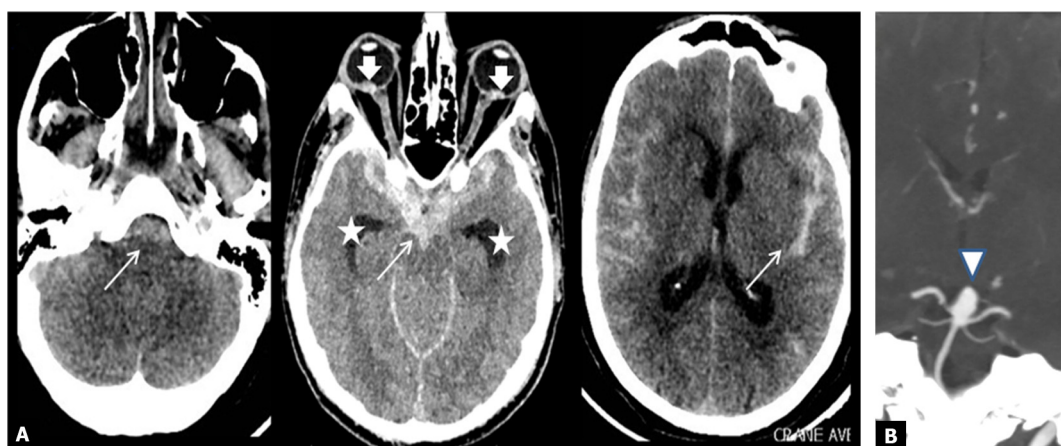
Axial cerebral CT without enhancement (A) and angiogram of the arterial circle at the base of the brain (B) on MIP reconstructions centered on the circle of Willis. Positive diagnosis of subarachnoid hemorrhage (A): unenhanced hyperdensity in the subarachnoid spaces (arrow) affecting the basal cisternae, motor cortex sulchi and interhemispheric fissure without flooding of the ventricles. Diagnosis of an early complication: early hydrocephalus with dilation of the temporal horns (star). Coexistent preretinal hemorrhage (Terson Syndrome, thick arrow). Diagnosis of cause (B): ruptured terminal basilar artery aneurysm (arrow head).
